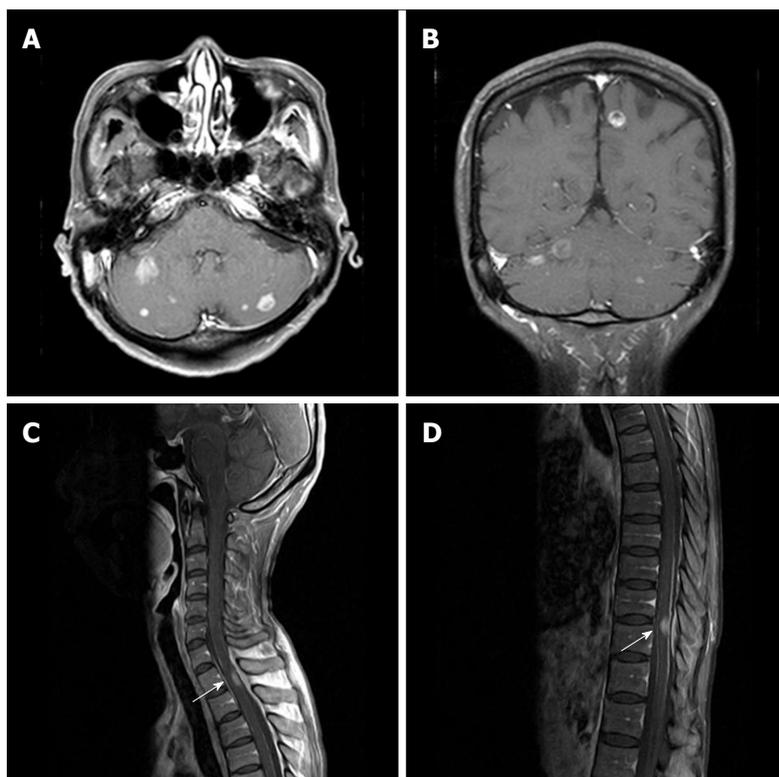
Magnetic resonance imaging of the brain and spine. On axial (A) and coronal (B) contrast-enhanced T1-weighted imaging of the brain MRI revealed multiple enhancing nodules at the cerebral and cerebellar hemispheres. On sagittal contrast-enhanced T1-weighted imaging of the spine MRI revealed eccentric nodular enhancement at spinal cord at T1/2 (C) and T10/11 (D). MRI: Magnetic resonance imaging.
